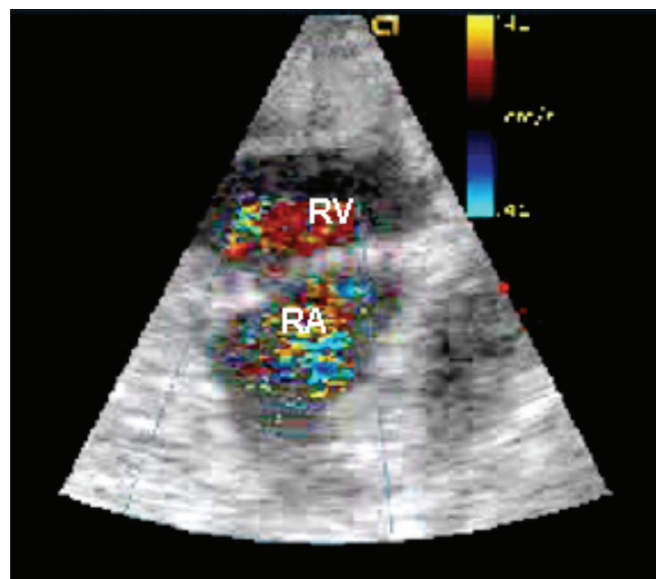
Echocardiography of tricuspid regurgitation: echocardiogram performed after induction of tricuspid regurgitation via partial excision of the posterior leaflet of the tricuspid valve. Regular flow of blood from the right atrium into the right ventricle is designated in red. Backflow of blood from the right ventricle into the right atrium due to 3+ tricuspid regurgitation is designated in light blue. RA indicates right atrium; RV, right ventricle.
